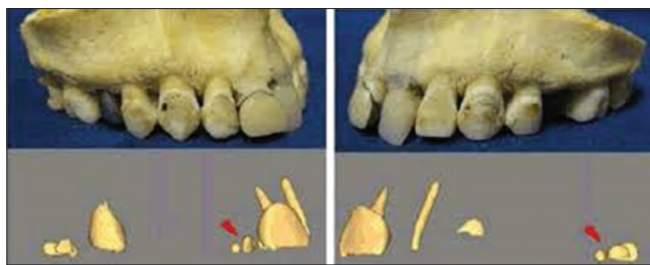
Image showing dental identification using dental cone-beam computed tomography (Image courtesy: [https://doi: 10.4172/2161-1122.1000332](https://doi.org/10.4172/2161-1122.1000332))
